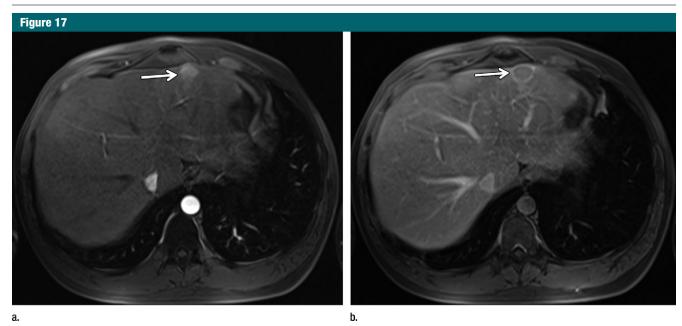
Intrahepatic splenosis misdiagnosed as hepatocellular carcinoma in a 51-year-old man with chronic viral hepatitis. This patient had a history of splenectomy. On fat-suppressed fast SE T2-weighted MR image (not shown), the peripheral lesion of the left liver lobe is moderately hyperintense. (a, b) On T1-weighted images (4.5/2.2; flip angle, 10°; section thickness, 4 mm), the lesion is hypointense on unenhanced images (not shown), (a) enhances (arrow) on the arterial phase image, and (b) is isointense on the delayed phase image. A hyperenhancing rim (arrow) is seen on the delayed phase image.
